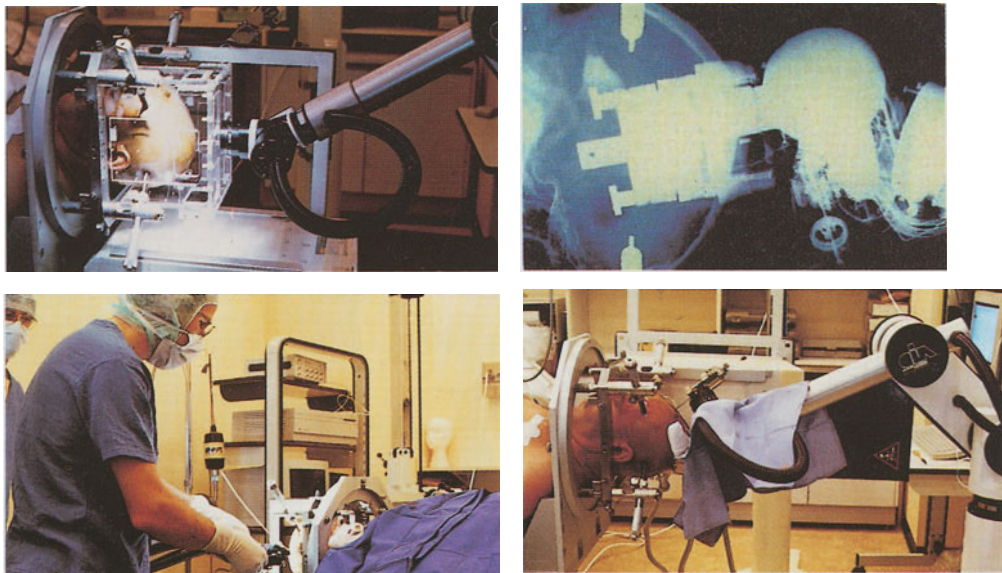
positioning of a linear guide through a 6-axis robot. At the beginning of each intervention, the robot carries a calibration cage on the head of the patient and reference X-ray images are acquired in order to calibrate the X-ray device and to link the robot coordinates with the image coordinates (up left). Then, the robot positions a linear guide in the location defined on multimodality images. Feedback control is achieved by checking the final location on X-ray images (up right). The power supply and the servo-control of the 6 axes is cut off, which is possible since reduction ratios have been increased. The surgeon finally introduces the tools (drills and probes) into the guide. Figures show the performance of a tumour biopsy (down
